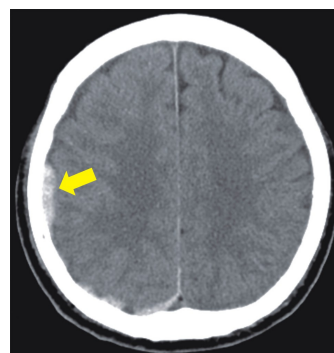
A brain CT scan reveals acute subdural hemorrhage in right cerebral convexity (yellow arrow).
